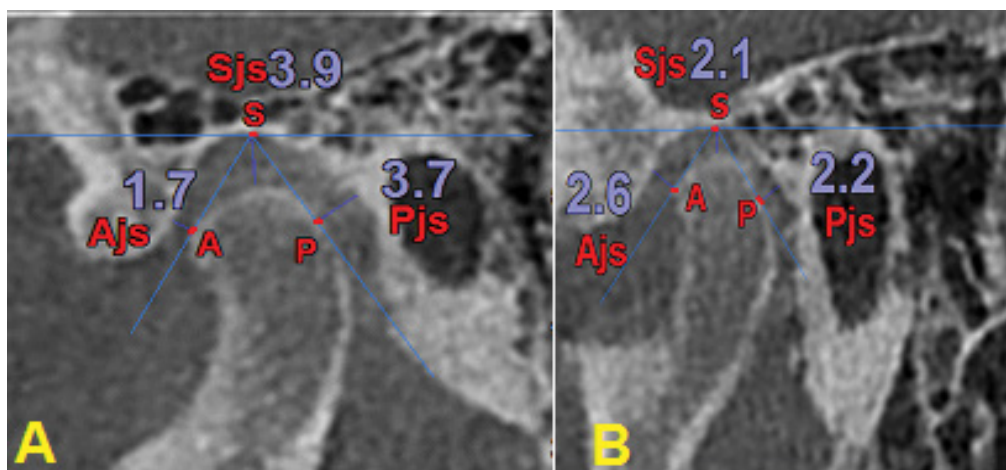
Measurement of joint space (Ajs, Sjs, and Pjs) on CBCT in sagittal section; A: healthy individual B: a patient with disc displacement
